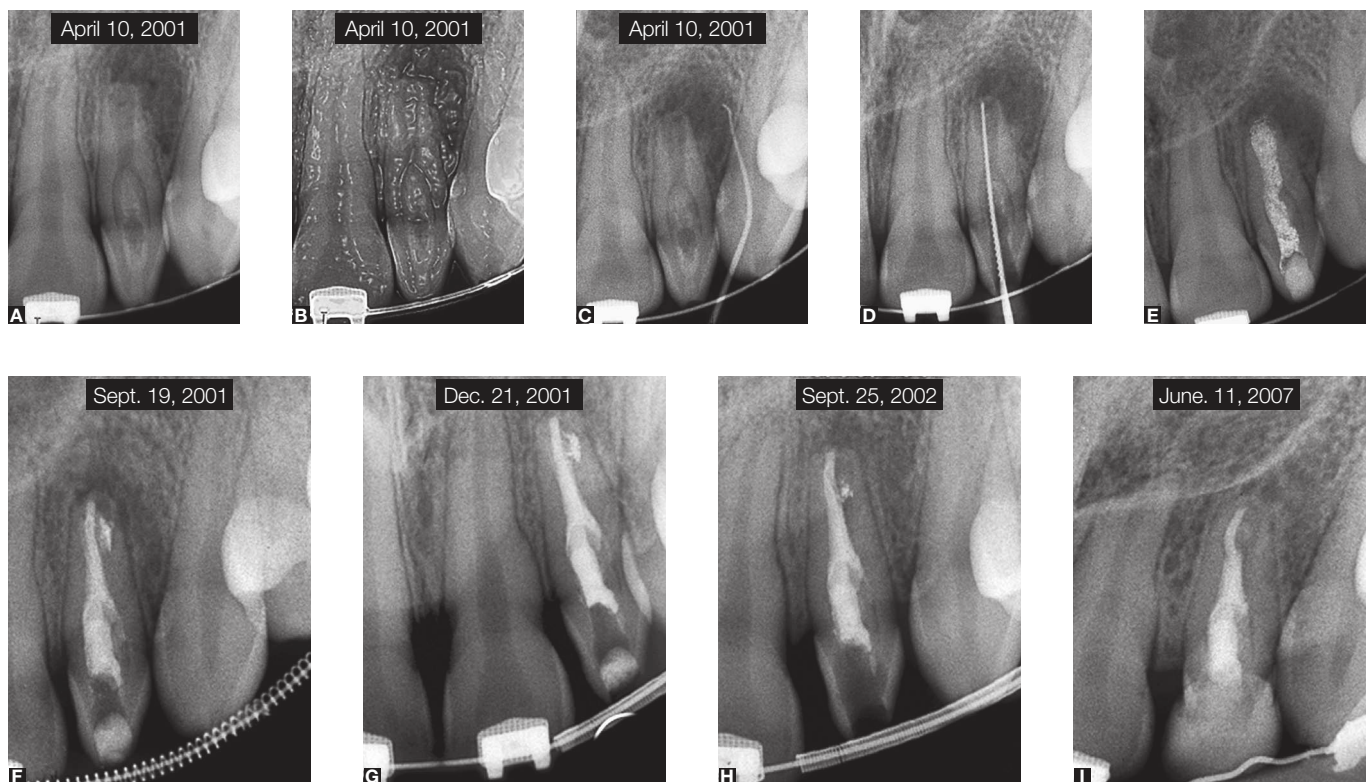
A) Initial radiograph; B) Graphic resource; C) Fistula tracing; D) Confirmation of working length; E) Intracanal dressing; F) Final radiograph; G) follow-up - 3 months; H) 1 year; I) 5 years and 9 months follow-up.
